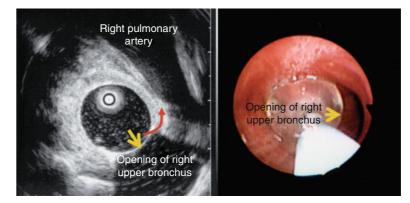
Tips for achieving optimum ultrasound images. Rotation of the ultrasound image so that it corresponds to the endoscopic images.
